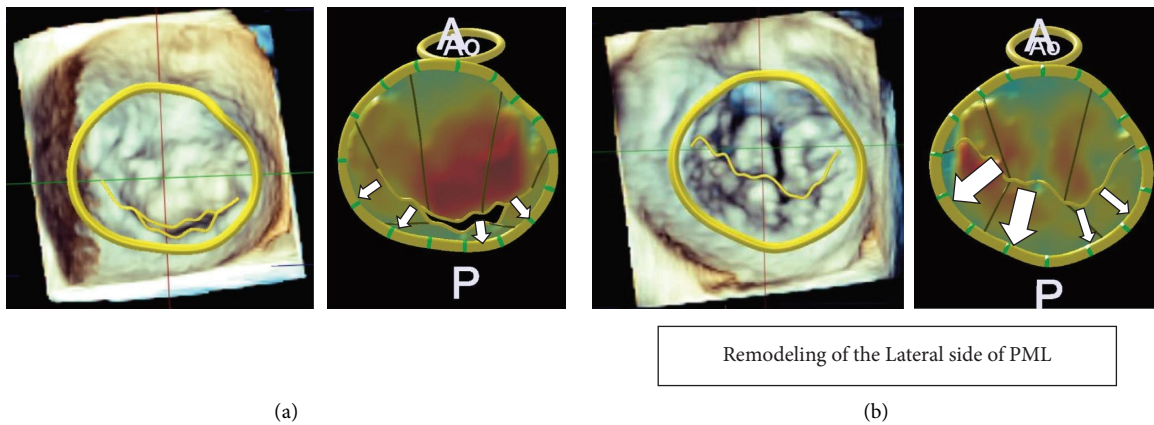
Geometric analysis of preoperative mitral valve of patients without (a) and with (b) recurrent mitral regurgitation after mitral annuloplasty for atrial functional regurgitation by three-dimensional transesophageal echocardiography. The white arrows show the remodeling of the posterior mitral leaflet. PML; posterior mitral leaflet.
